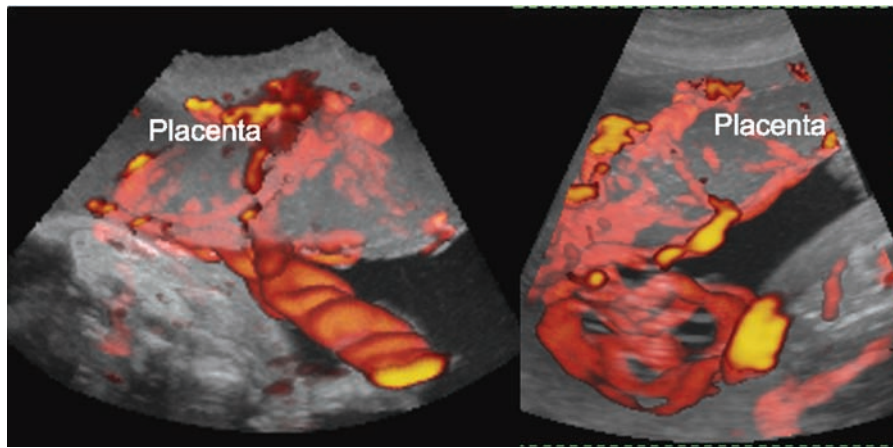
3D power Doppler ultrasound showing a central insertion of the umbilical cord (left) and a velamentous insertion (right).
